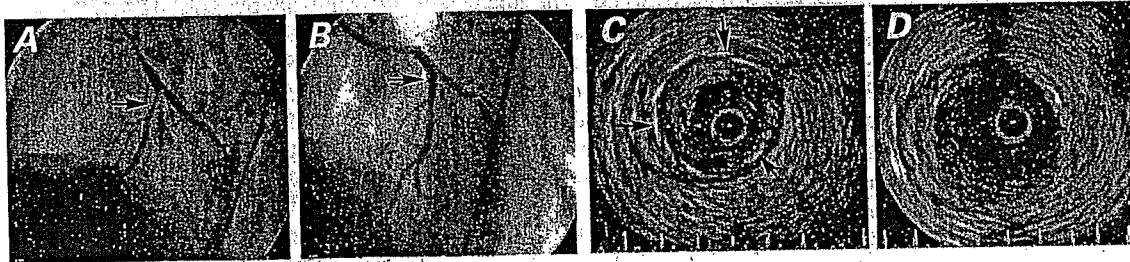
Angiograms and intravascular ultrasonographic (IVUS) images of in-stent restenosis before and after directional coronary atherectomy (DCA). A) Angiogram shows 90% diffuse in-stent restenosis in the left anterior descending coronary artery segment 6 (arrow). B) The restenosis is abolished after DCA (as shown by arrow). C) Before DCA, IVUS shows the stent (arrows) and severe neointimal proliferation within the stent. D) The enlarged lumen is shown after DCA, when the stent and neointima were pulled out.
